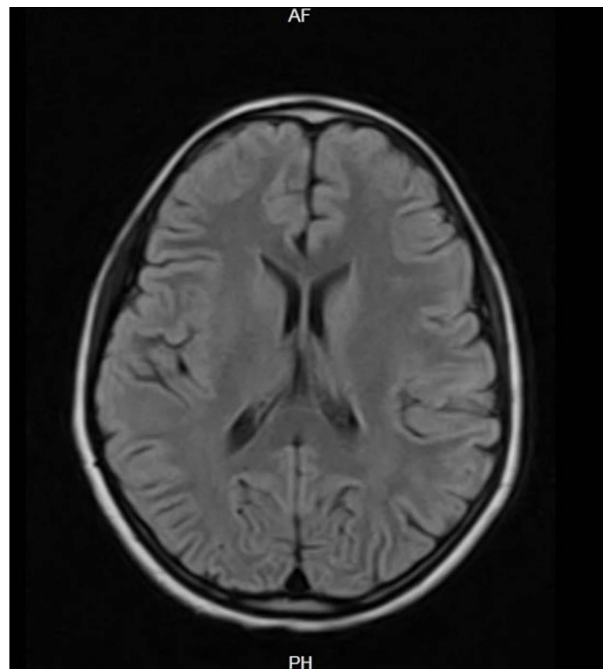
Cerebral MRI image with no abnormalities of Case 1.
